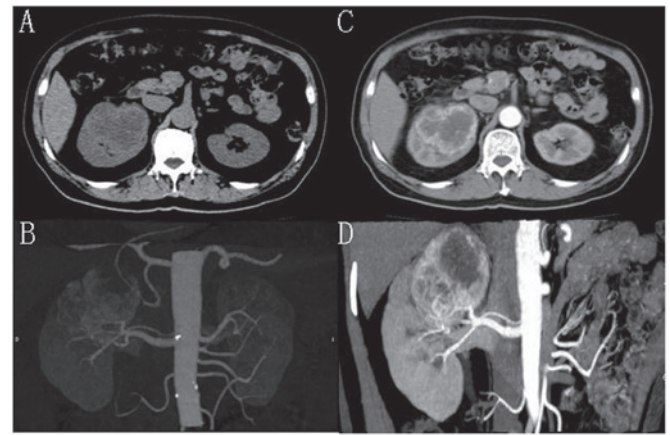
Computed tomography (CT) scan of kidneys. (A and B) A 6.5x6.2-cm round hypodense mass [48.2-54.2 Hounsfield units (HU)] in the upper pole of the right kidney (non-contrast CT); (C and D) a heterogeneously enhanced mass with a non-enhanced hypodense region in the centre.
